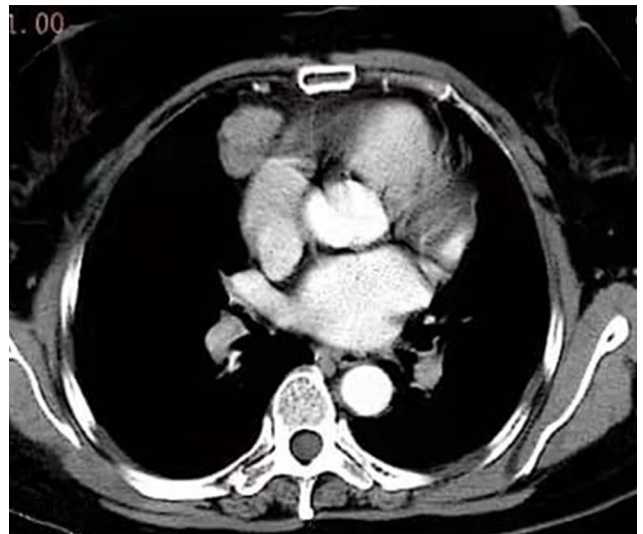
(a) Chest CT images of the mediastinal masses. (b) Thymic veins were exposed. (c) The mirror, main operating, and assistant operation holes were made at the fifth intercostal space on the right anterior axillary line, and at the fifth and fourth intercostal space on the right midaxillary line.
